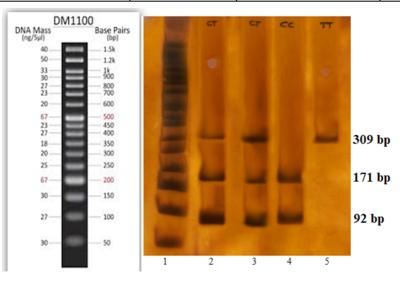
PCR-based restriction fragment length polymorphism analysis for FLT-1 gene at rs2296283 locus after enzymatic digestion using *HaeIII* restriction enzyme. Three genotypes TT, CT, CC were observed. Lane 1: 50 bp DNA marker; Lane 2 and 3: heterozygous CT; Lane 4: homozygous CC and Lane 5: homozygous TT in Behcet's patients.
